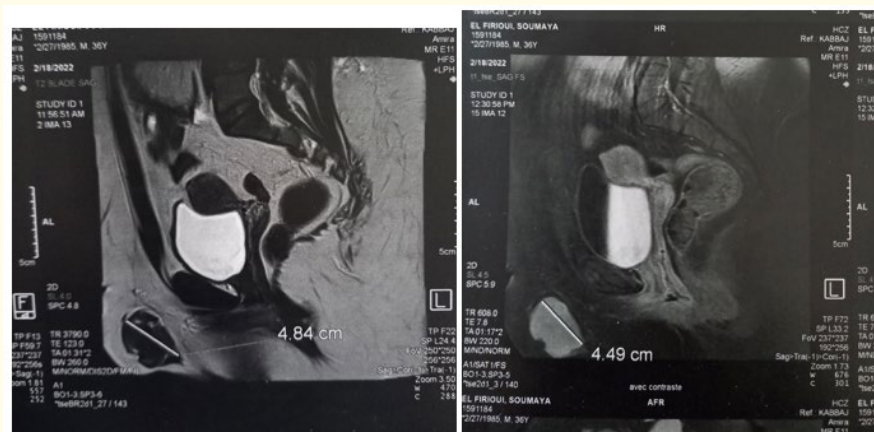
Pelvic MRI, right formation with bumpy borders and more heterogeneous, less enhanced after injection.
